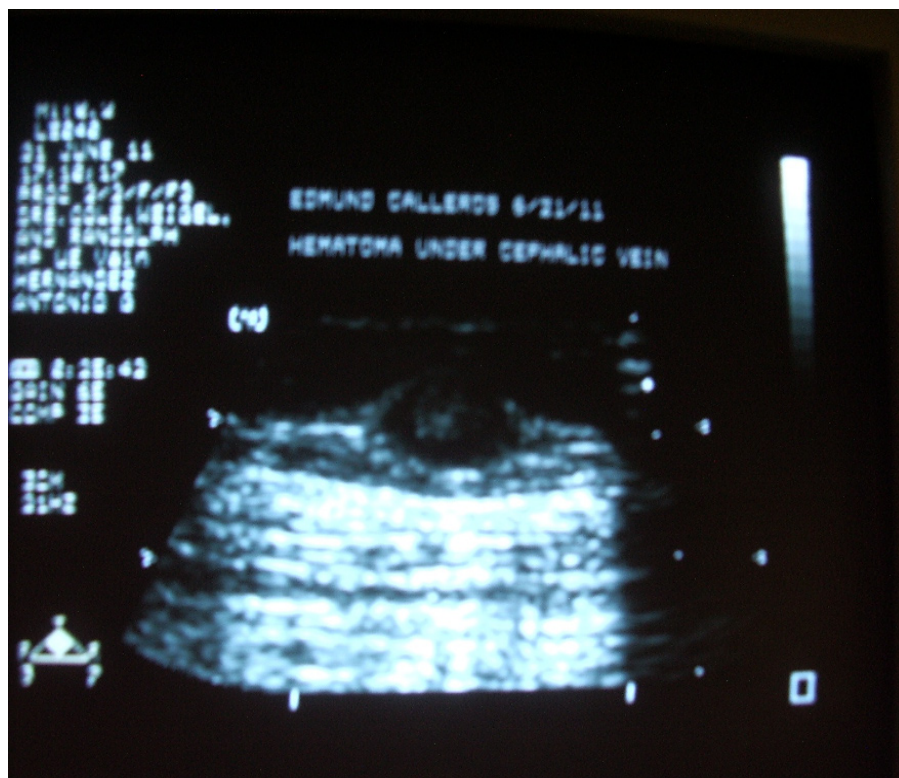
Ultrasound image of the draining cephalic vein in the longitudinal plane. The hypoechoic mass with internal echoes is hematoma under the vein that has pushed the vein to close.
